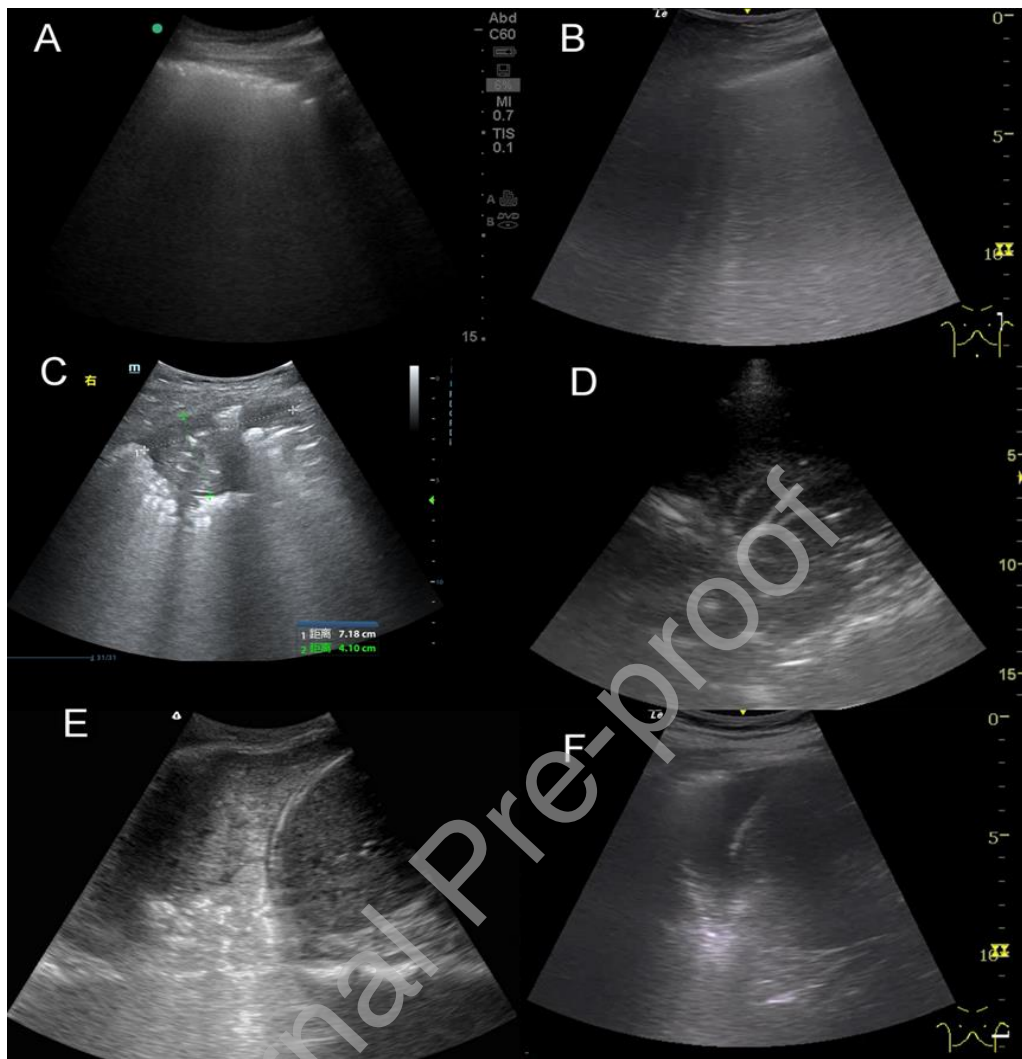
Typical lung sonographic findings in Coronavirus Disease 2019 patients.
